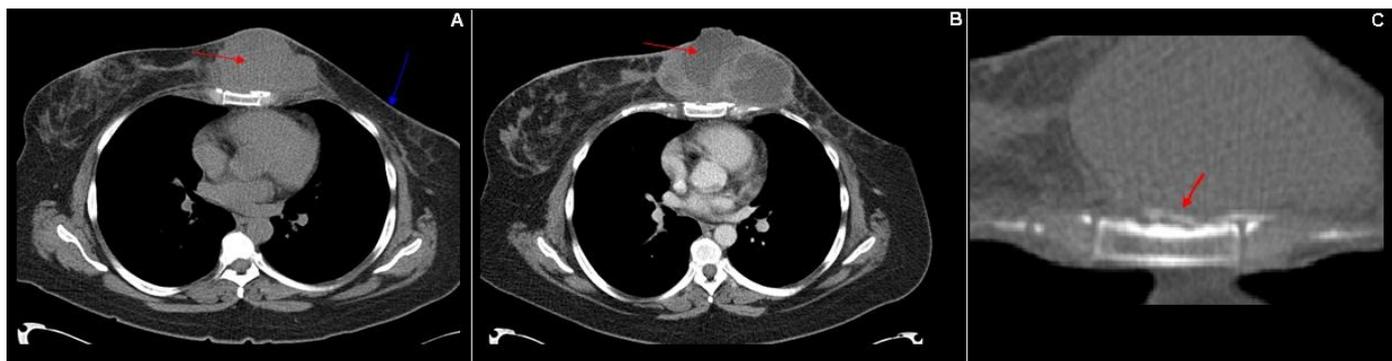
43 year old female with malignant phyllodes tumor. CT of the chest. 76 mAs, 120 kVP, 5.00 mm slices.
